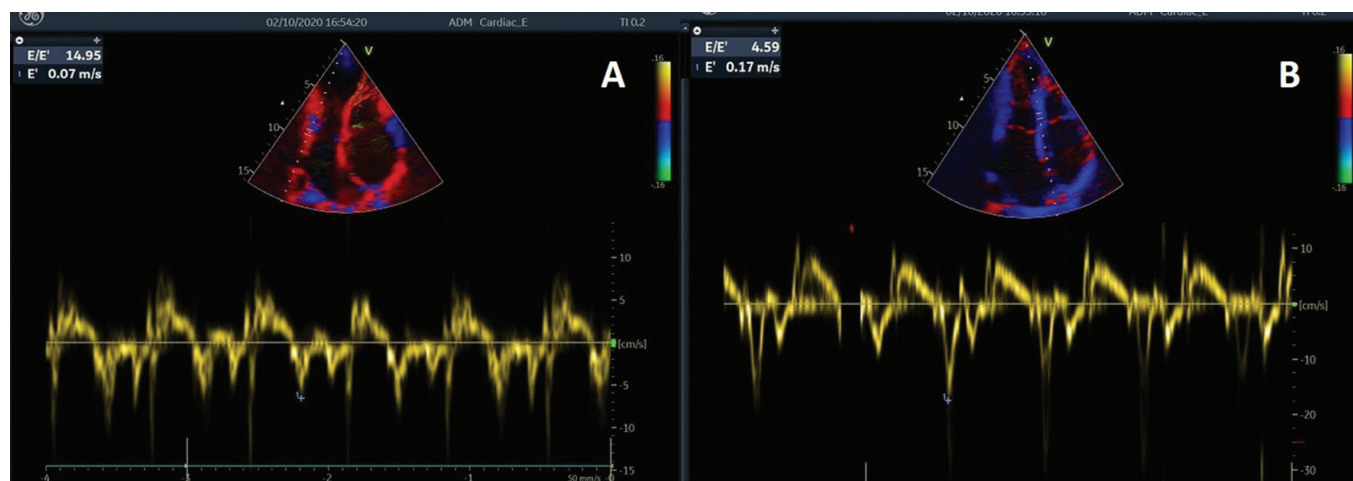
(A) Mitral lateral E' velocity was 7 cm/sec. (B) Mitral annular septal E' velocity was 17 cm/sec on tissue Doppler
